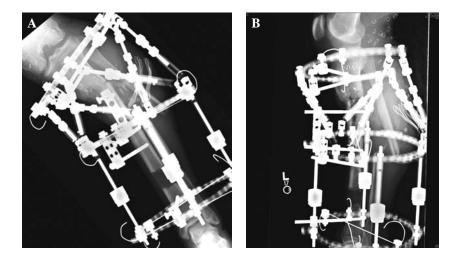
Anteroposterior and lateral radiographs after placement of Taylor Spatial Frame with acute shortening and angulation to obtain soft tissue coverage. A distal corticotomy with proximal bone transport was performed to restore limb length.
